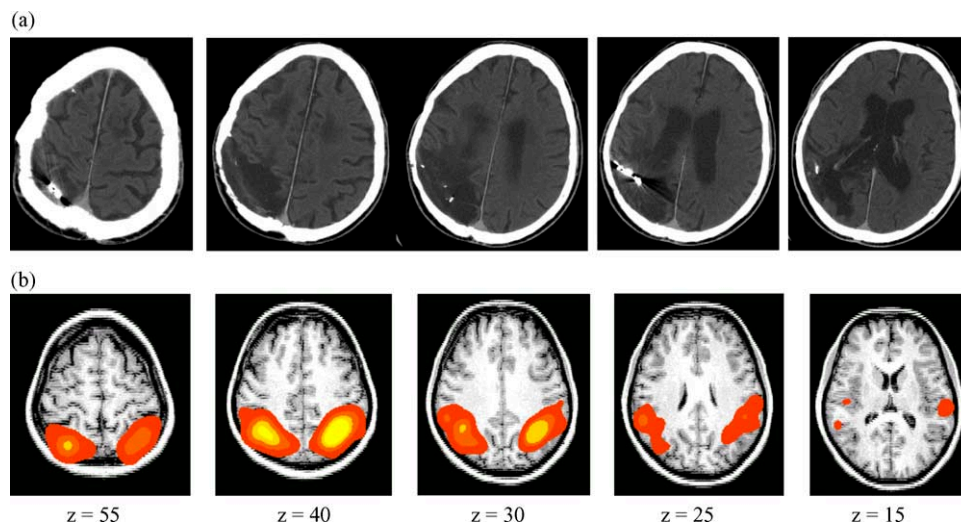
(a) CT scan of patient RB revealing right parietal, temporal, and occipital damage and (b) results of our meta-analysis of right parietal regions reported in studies of verbal working memory. Note that  $z$ -values are estimated for RB's CT scans based on the determination of the AC-PC line observed in his scans (not presented here).
